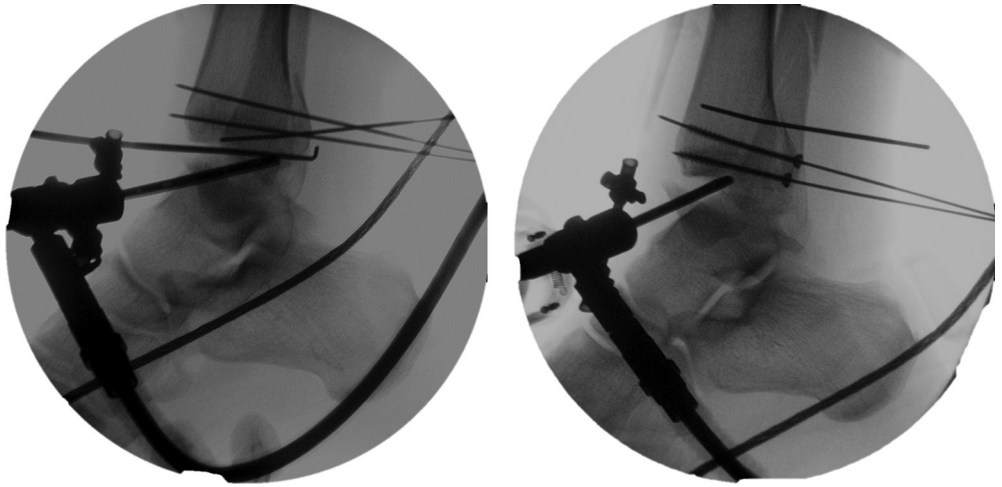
Reduction of left ankle syndesmosis under arthroscopic visualization from an anteromedial portal with evaluation of syndesmotic diastasis with a calibrated nerve hook. Anteroposterior radiograph showing the arthroscopic reduction held with guidewire followed by fixation with 2 screws using a percutaneous technique.
